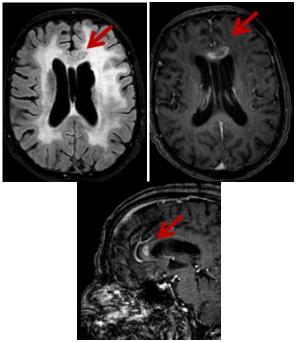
Cerebral contrast-enhanced MRI scan in different planes showing periventricular and callosal contrast enhancing lesions
